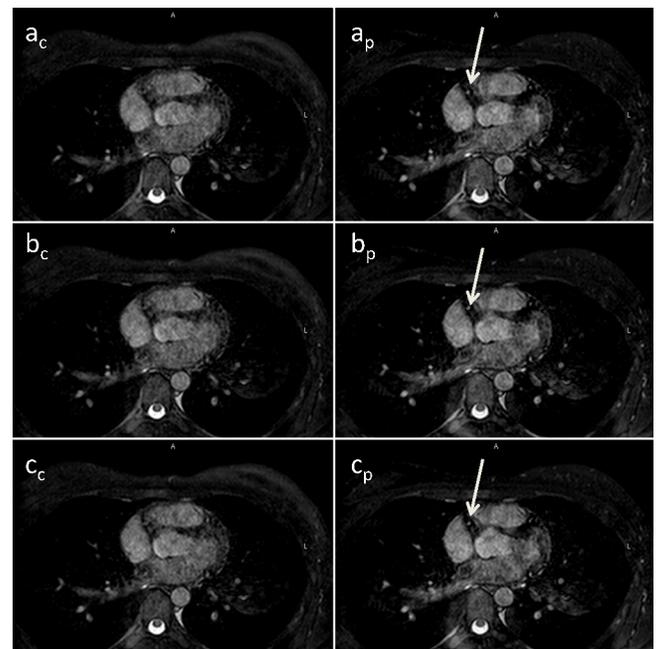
Consecutive slices of whole-heart MRI reconstructed by conventional pencil beam (a_c, b_c, c_c), and projection-based (a_p, b_p, c_p) navigators. Arrows indicate RCA better visualized in images reconstructed by projection-based navigator.
